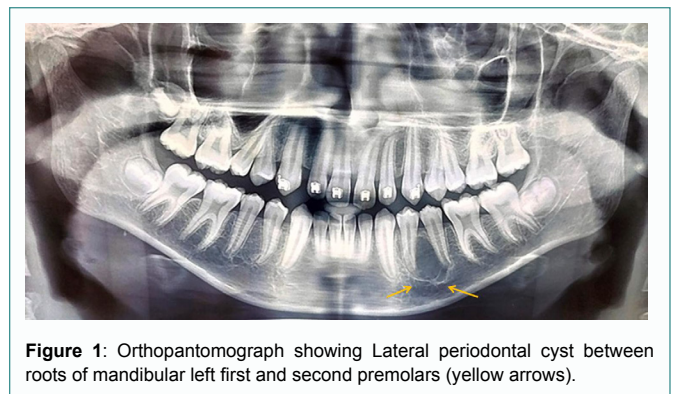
Orthopantomograph showing Lateral periodontal cyst between roots of mandibular left first and second premolars (yellow arrows).
